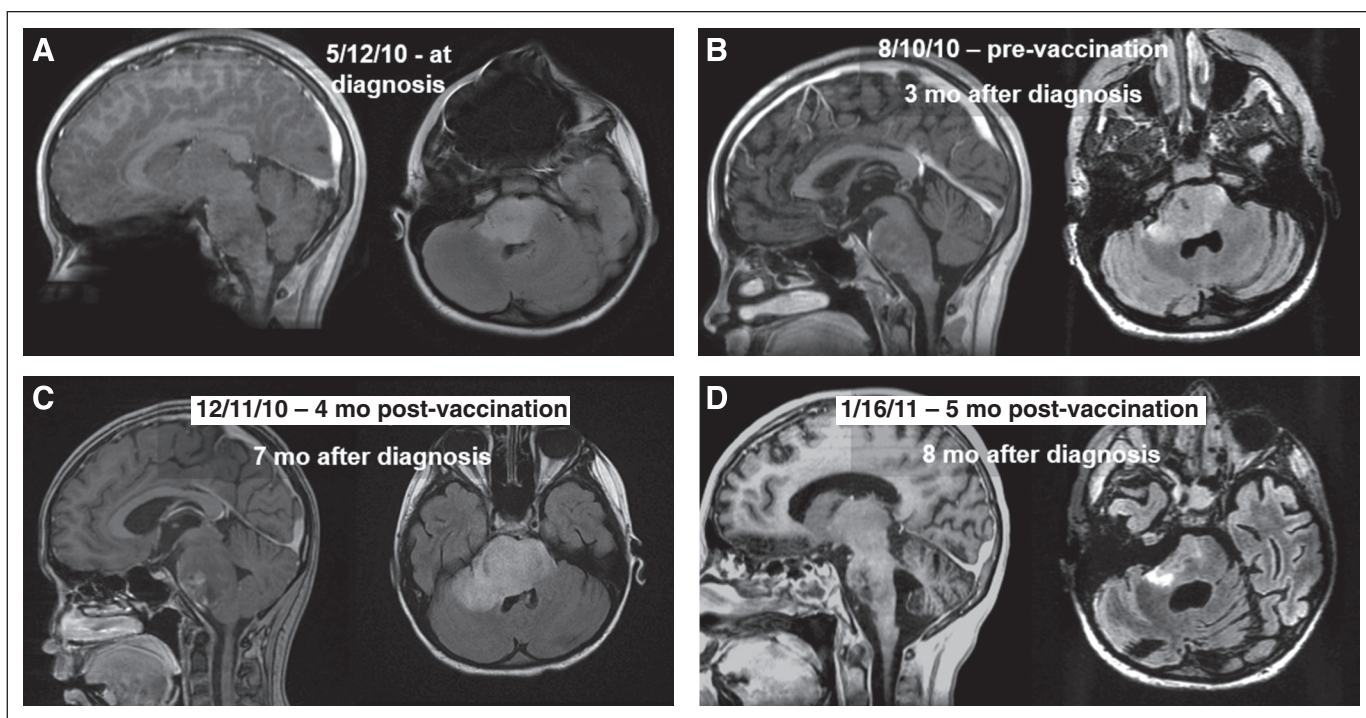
Magnetic resonance imaging (MRI) results in a responding patient (patient 11), with transient pseudoprogression. In each panel, sagittal T1-weighted gadolinium-enhanced images are on the left, and axial fluid-attenuated inversion recovery images are on the right. (A) MRI scan at diagnosis. (B) MRI scan before vaccine therapy (3 months after diagnosis and start of irradiation). Tumor is unchanged from baseline. (C) Four months after the start of vaccination, the patient had tumor enlargement, increased enhancement, and symptomatic worsening. High-dose dexamethasone was started. (D) The MRI scan shows dramatic reduction of enhancement and mass effect 1 month later (1/16/11). Dexamethasone was weaned, and vaccination was subsequently resumed. The partial response status was then maintained until 18 months after diagnosis.
